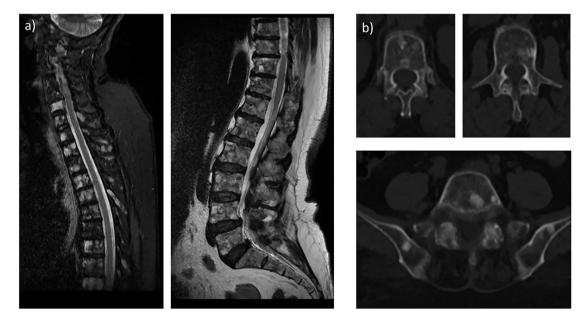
(a) The contrast-enhanced T2 images of magnetic resonance imaging (MRI) showed abnormal bone marrow signals across almost the entire spine, ribs, shoulder blades, hips, and pelvis, suggestive of widely spread bone metastases. (b) Follow-up computed tomography (CT) imaging demonstrates that several bony lesions have become denser (increased sclerosis), suggesting the healing response. Invasive lobular carcinoma (ILC) accounts for a notable portion of invasive breast carcinomas, developing insidiously in roughly 10-15% of cases.
